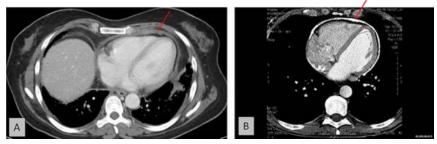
(A) CT of the chest showing increased pericardial thickness (*red arrow*). (B) CT of the chest showing circumferential calcification of the pericardium (*red arrow*) in a 40-year-old man who became short of breath and developed fluid retention. Video 20 (available at www.onlinejase.com) of cine CT shows septal bounce and severe calcification around the right side of the heart.
